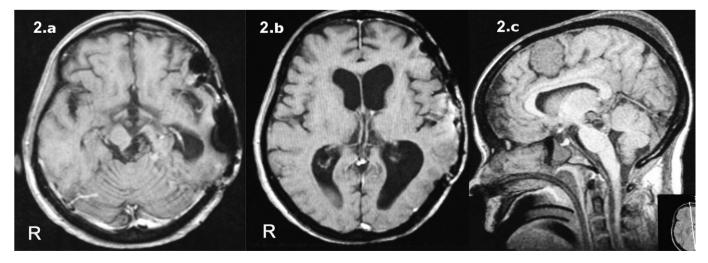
Postoperative axial (a, b) and sagittal (c) T1-weighted MRI showing complete resection of the cavernoma with preservation of the surrounding hemosiderin ring and complete removal of the left temporal meningioma, with resolution of sylvian cistern exclusion.
